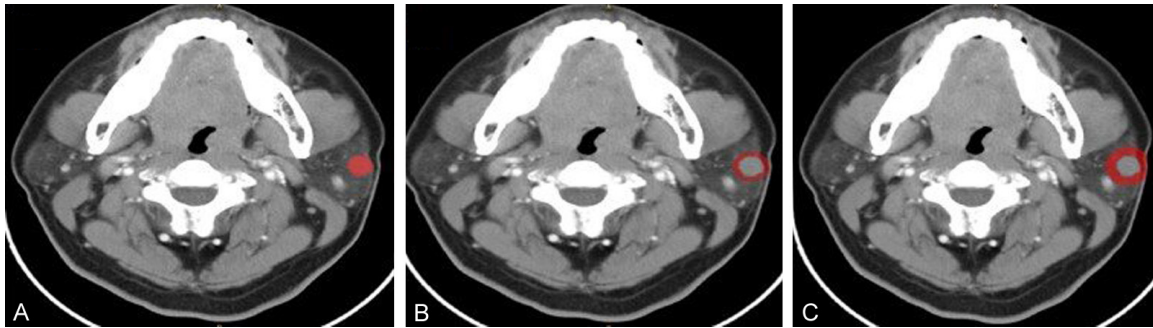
Contrast-enhanced CT image from a pleomorphic adenoma patient, highlighted regions represent the primary tumor (A) and peritumoral region of 2 mm (B) and 5 mm (C).
